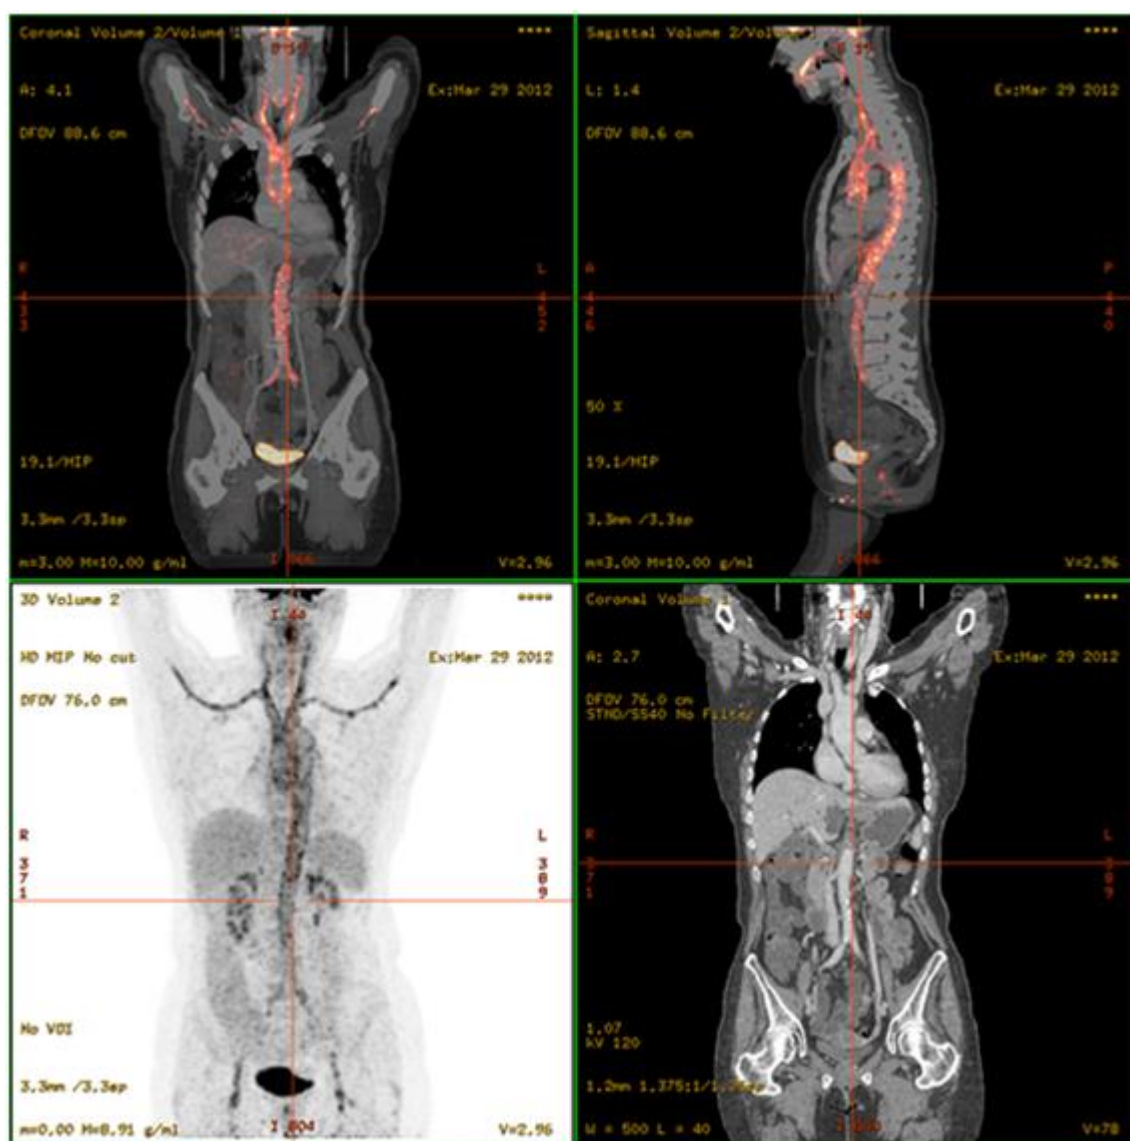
PET/CT showing severe vasculitis
